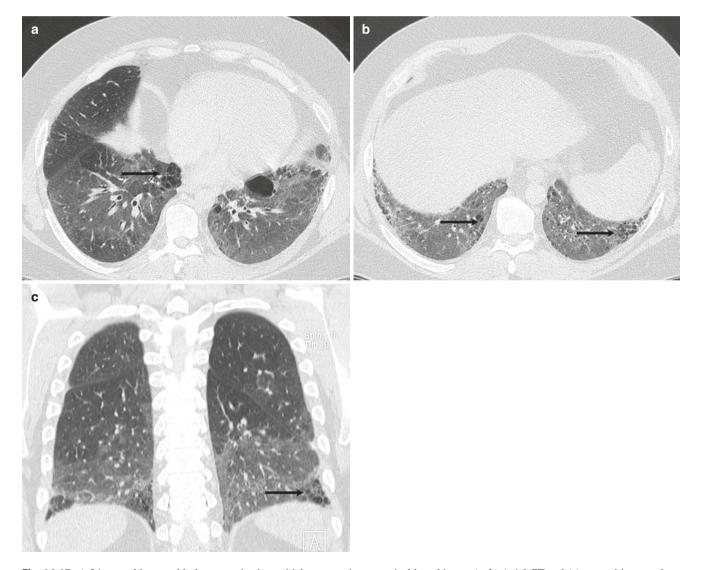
A 34-year-old man with desquamative interstitial pneumonia on surgical lung biopsy. (a, b) Axial CT and (c) coronal images show confluent ground-glass opacities in the lower lungs with small cysts formation (black arrows) within abnormal regions
